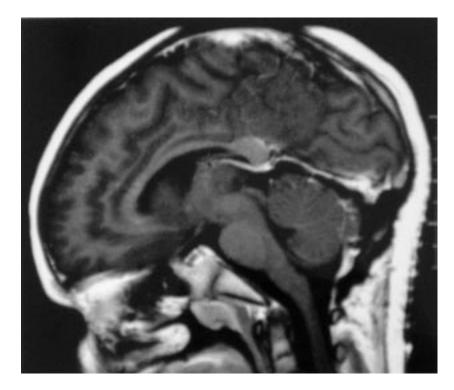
Postoperative sagittal T1-weighted magnetic resonance image of the brain demonstrating gross total resection of the cyst and decompression of the pineal gland.
